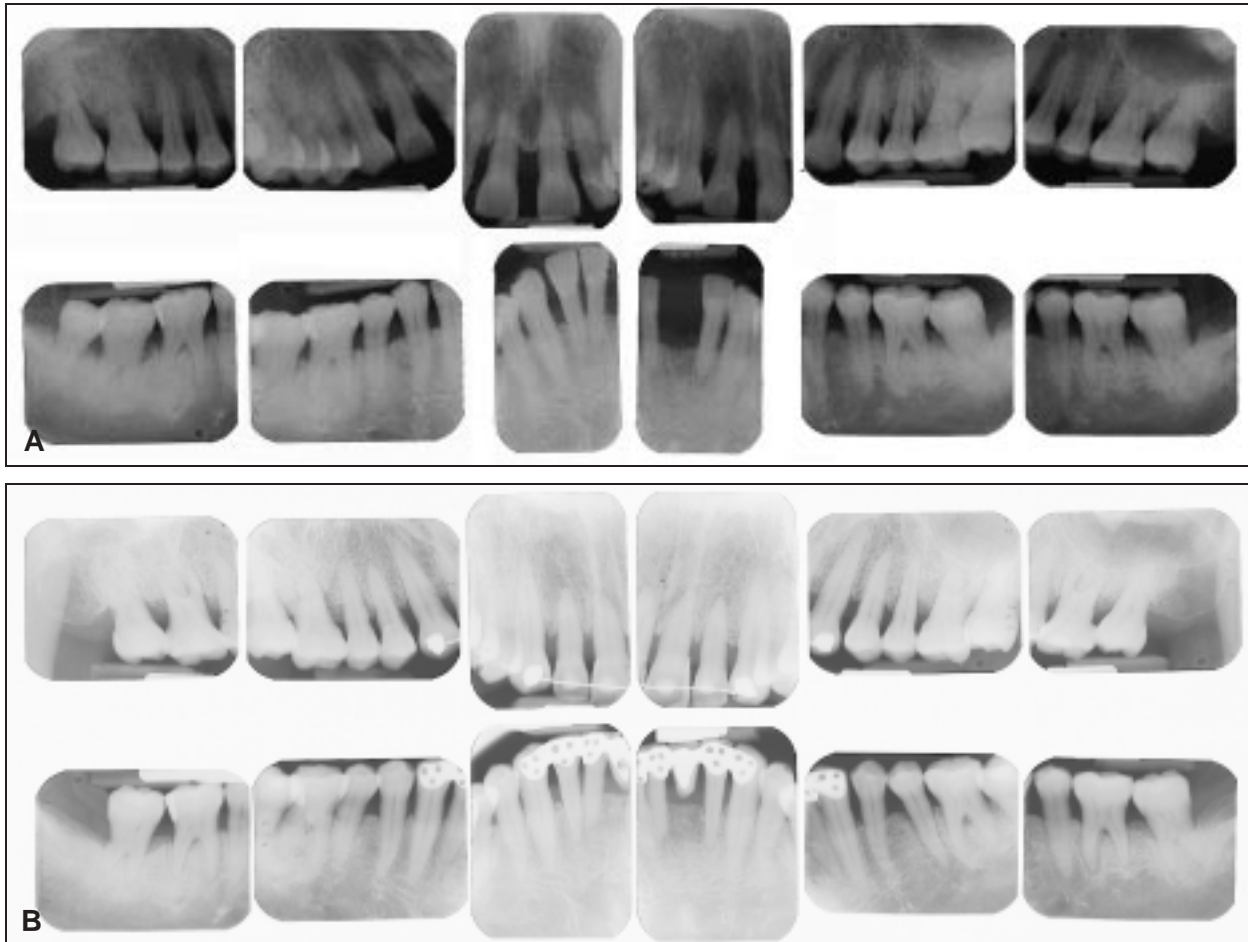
A. Periapical radiographs before treatment, showing reduced periodontal support. B. Radiographs after treatment, showing improved periodontal condition after orthodontic intrusion.
